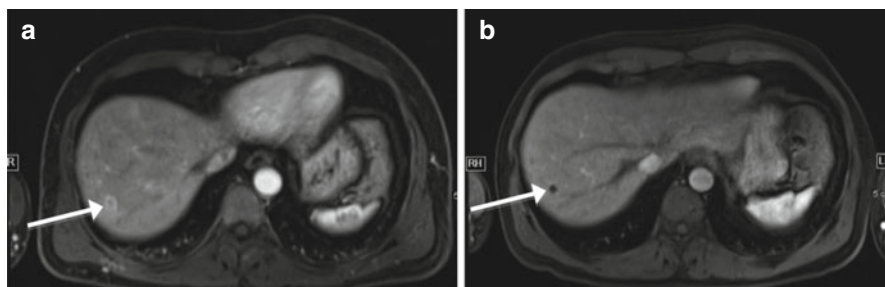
(a). MRI imaging demonstrating small peripheral liver GIST metastasis. (b). Cystic changes in liver GIST metastasis seen on MRI following TKI treatment for 5 months duration as denoted by *white arrows*
